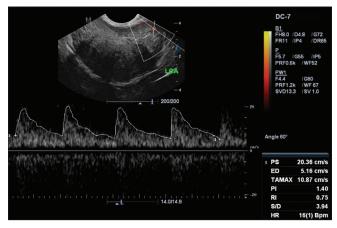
Transrectal triplex power Doppler sonogram of the left capsular artery at the posterolateral aspect of an enlarged prostate gland
